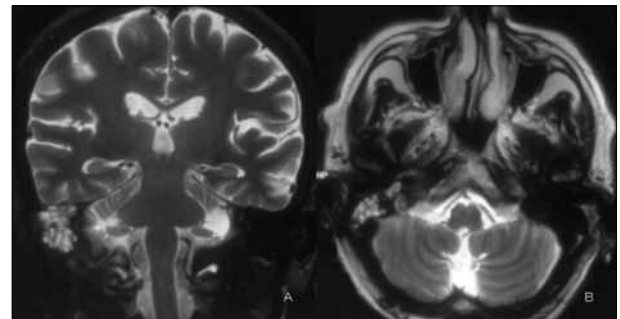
MR imaging: purulent collection involving skull base (A – coronal view; B – axial view)
